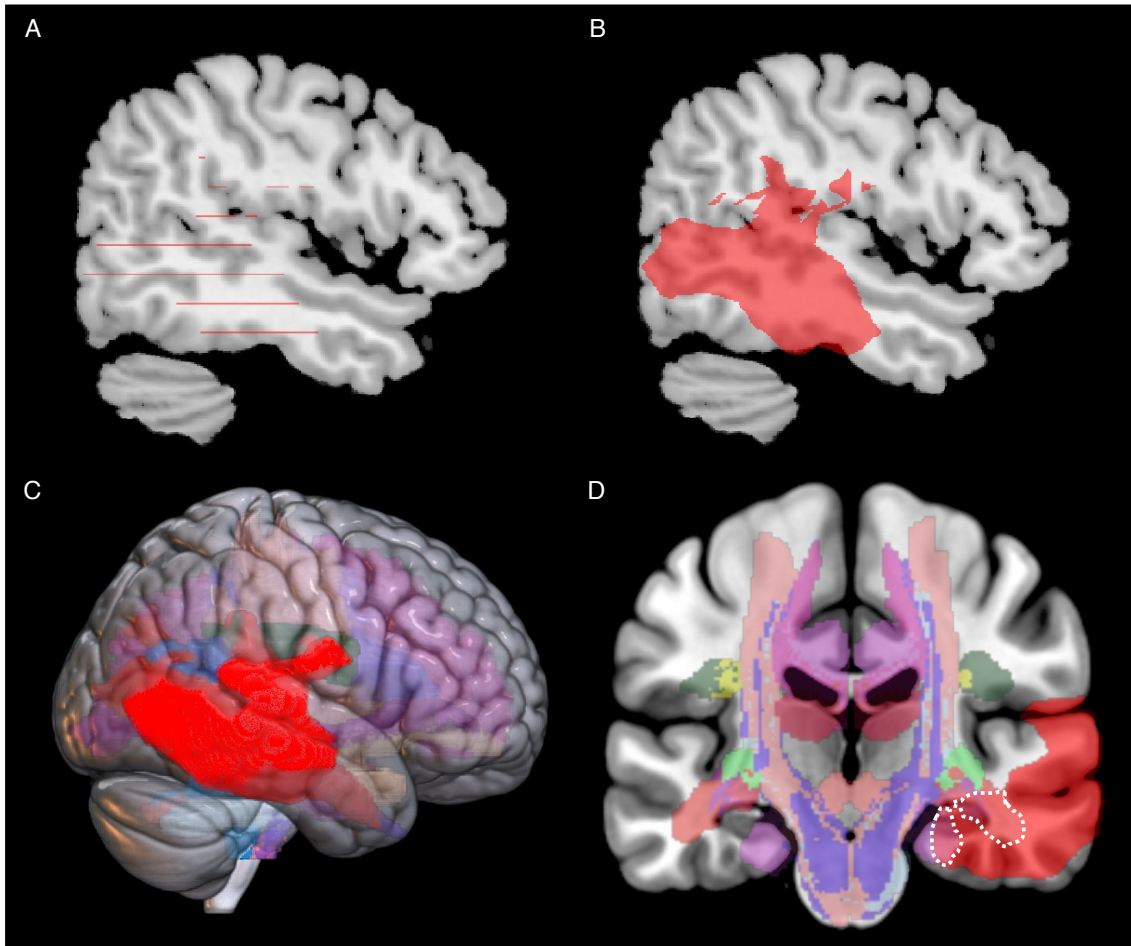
Interpolation and overlay onto a brain atlas to generate anatomical data from CT radiographs. A. Sagittal view of segmentations (red) in serial axial slices. B. Interpolation of segmentations to render a 3D volume. C. External view of the 3D volume. D. Overlay of the 3D volume onto a white matter atlas (natbrainlab) to extract anatomical data describing %damage to each region.
